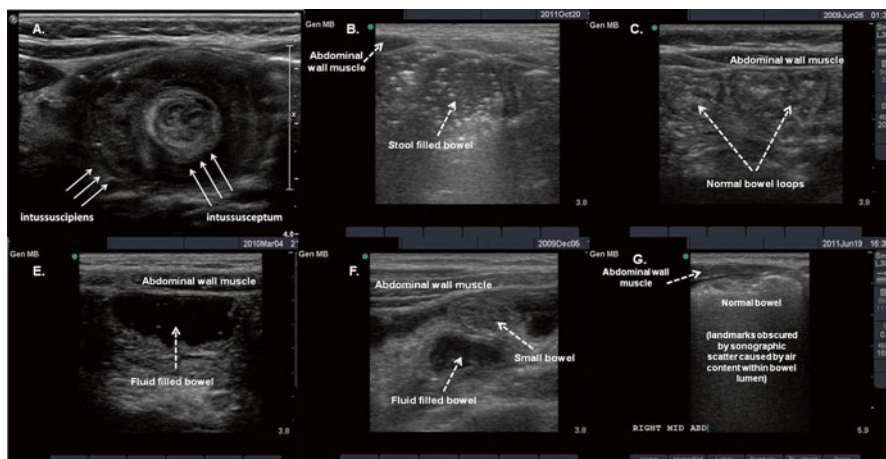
Image (a) depicts the classic “target sign” appearance in transverse orientation of an ileocolic intussusception. Images (b–g) represent examples of normal bowel as seen by high frequency ultrasound
